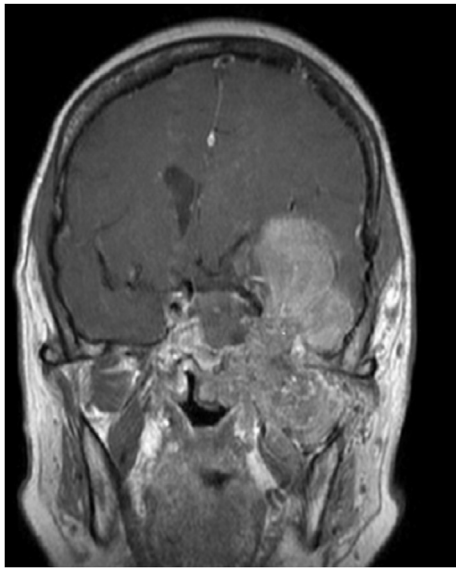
Post-contrast T1-weighted coronal image showing the extent of tumor infiltration from its epicenter in the left greater sphenoid wing into the surrounding structures and intra-cranially.
